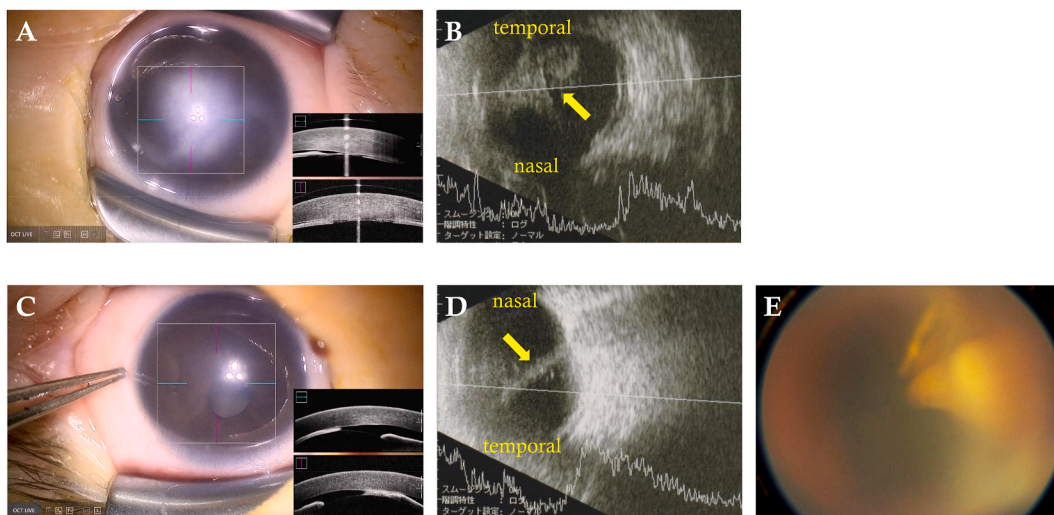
Case 2: peri-operative findings. Both eyes had flat anterior chambers with iris adhesions to the cornea (A, C). The right eye had a significant corneal opacity which prevented visualization of the posterior pole (A), while the left eye had poor mydriasis due to posterior synechiae (C). On B-scan ultrasonography, the right eye had a total retinal detachment (arrow) (B) and the left eye had a fibrovascular stalk with a partial TRD superotemporally (arrow) (D). The retinal stalk and TRD were confirmed by RetCam imaging (E).
